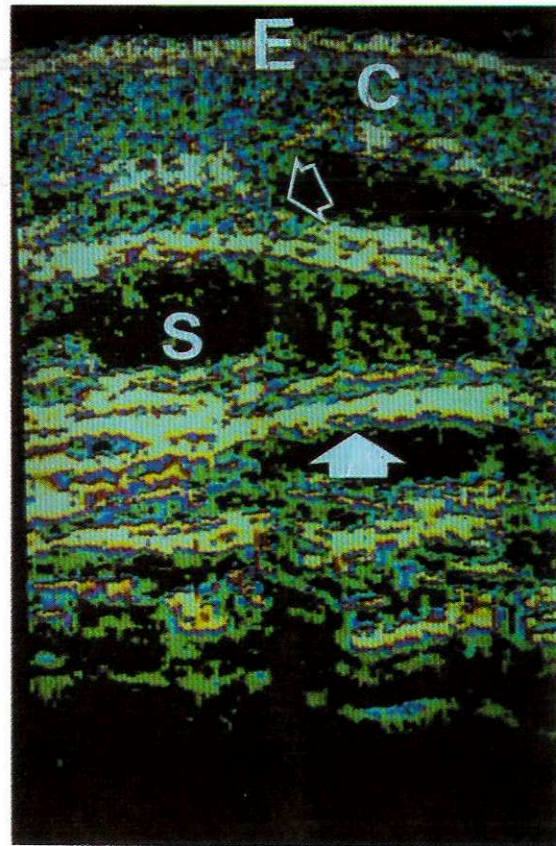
Ultrasound B-scan of the plaque from Fig. 11 two months later (Case Study 5) (E: entry echo; C: corium; S: subcutaneous fatty tissue; closed white arrow: hyperechoic bands of connective tissue; open white arrow: homogeneous area).
